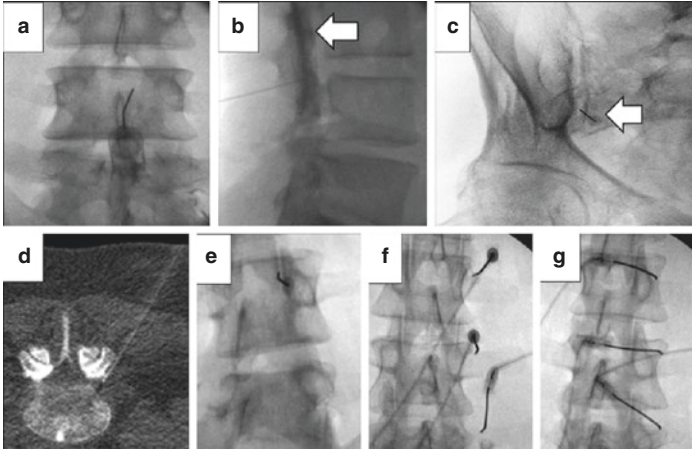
Epidural steroid injection ((a) anterior-posterior projection, (b) sagittal projection with arrow identifying contrast layering in the epidural space). Right sacro-iliac joint steroid injection ((c), arrow). Spinal nerve root block at the left L4 neuroforamen under CT guidance (d). Steroid injection into the right L4/5 facet ((e), obliqued anterior-posterior view). Rhizotomy for the right L2-L4 median branch nerves ((f) anterior-posterior projection, (g) obliqued projection)
